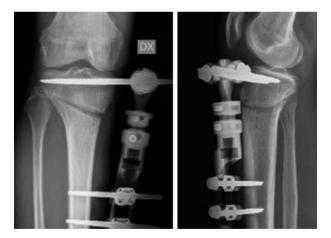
X-ray performed 30 days after osteotomy with good correction and initial signs of bone callus formation
